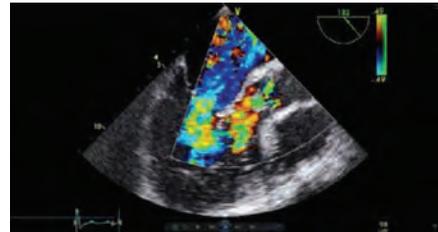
Transesophageal Echocardiography, color Doppler. Apparent flow in diastole within the "wind-sock".
